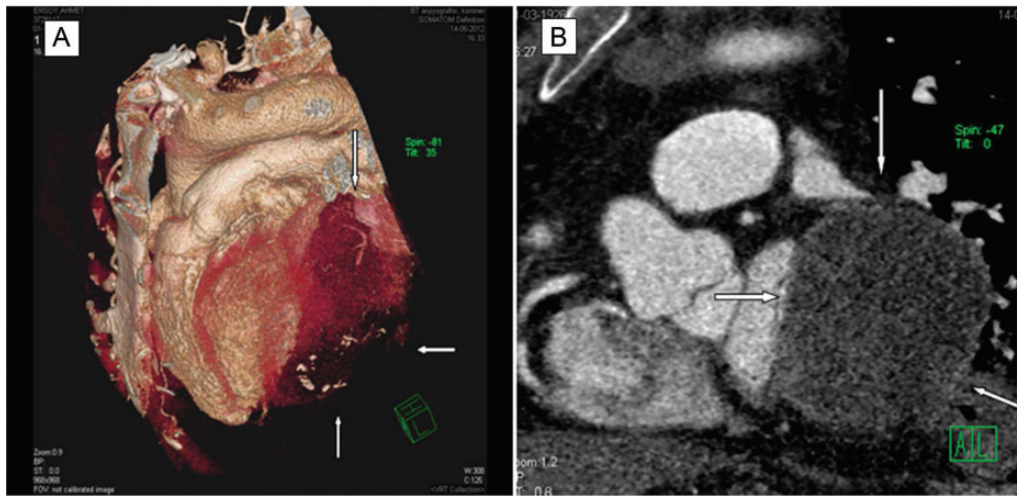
CT angiography scan showing hydatid cyst in the infero-lateral of the left ventricle and left atrium. (A) Three dimensional view and (B) Normal section.
